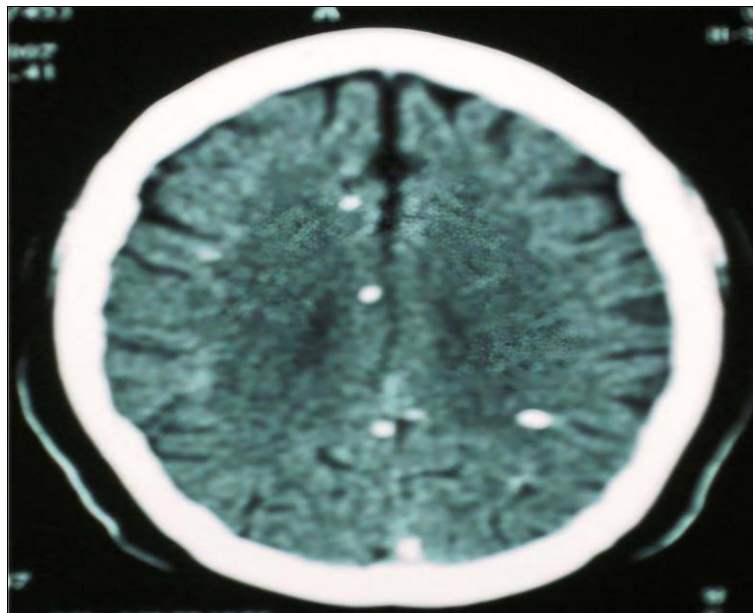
Calcified granuloma cyst in brain parenchyma (non contrast CT scan)
